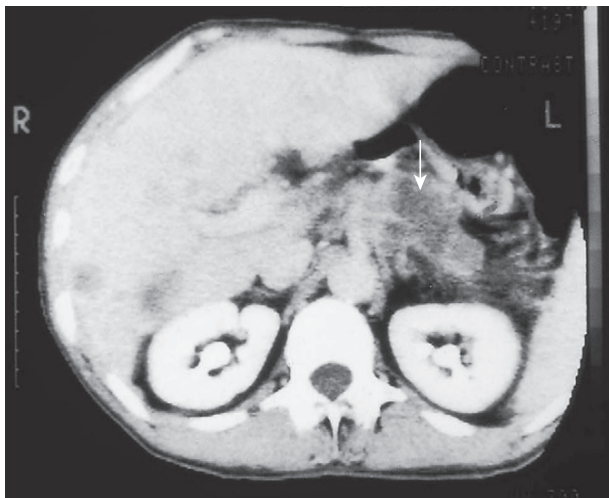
CT scan of the upper abdomen. There is a carcinoma in the pancreas (arrow).
